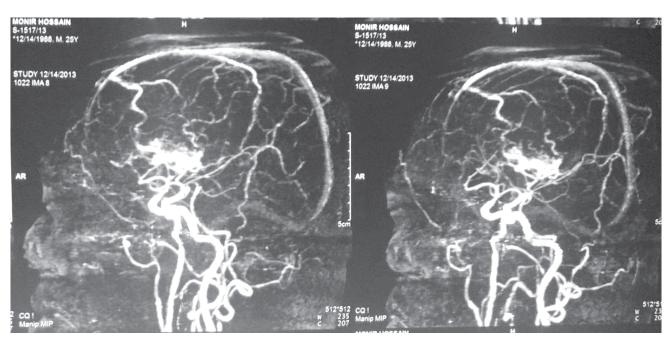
CTA of Brain showing AVM nidus
